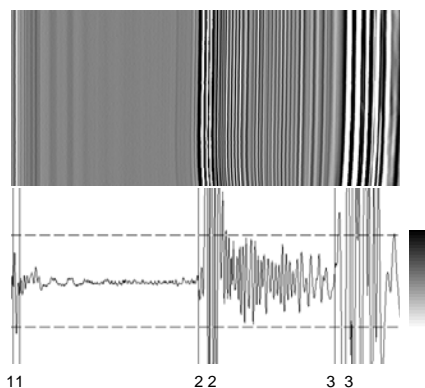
Results of ultrasonic monitoring of transient shrinkage induced by changing 0.15 M saline to 2 M saline. M-mode image (top); A-mode signals with tracking windows (bottom).
